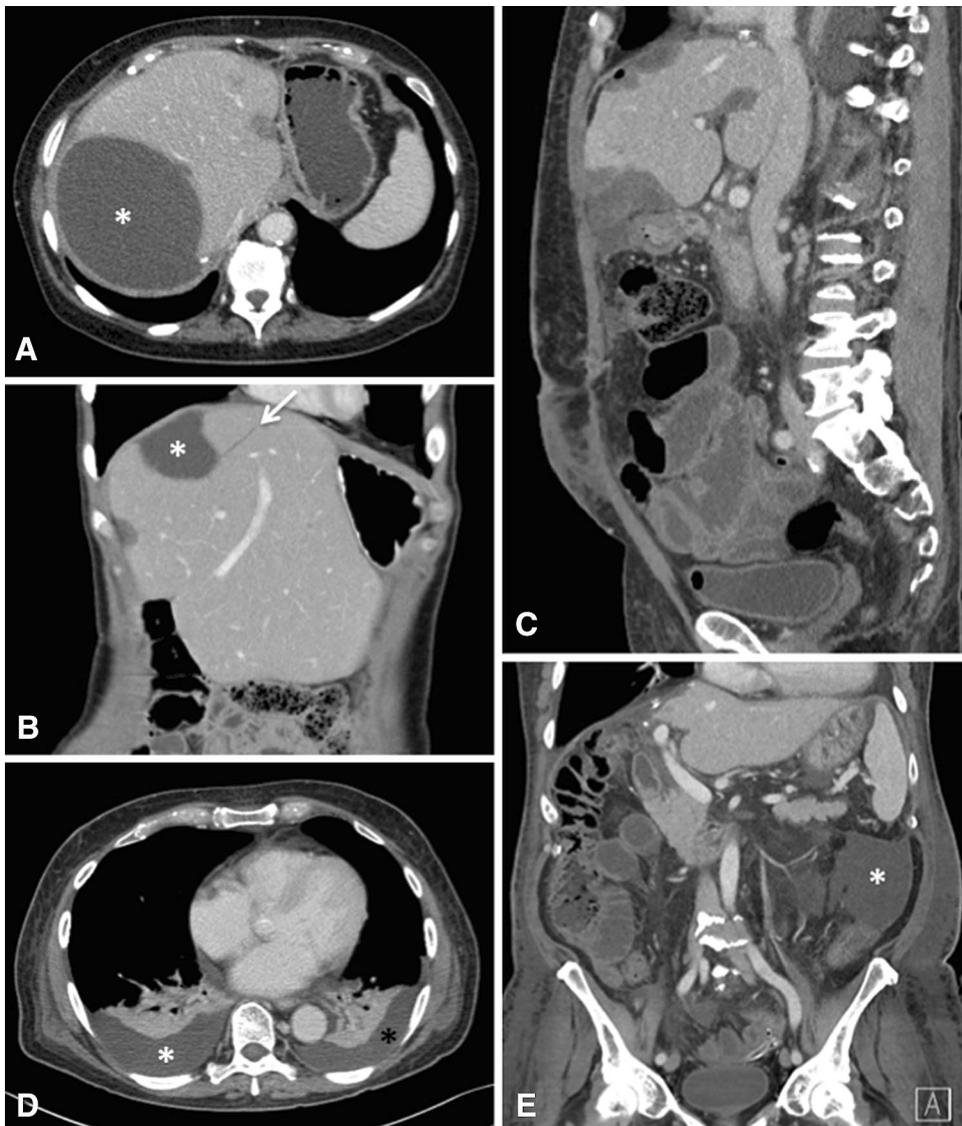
Third imaging (IM3): complication assessment: postoperative CT scans are performed after the second surgery to identify potential complications: A axial-enhanced CT image of a 66-year-old woman with a biloma (*asterisk*). B Coronal-enhanced CT image of a 29-year-old woman with a biloma (*asterisk*) and a biliary fistula (*black arrow*). C Sagittal-enhanced image of a 66-year-old male with an adynamic ileum. D Axial-enhanced image of a 55-year-old woman with bilateral pleural effusion. E Coronal image of a 64-year-old female with ascites.
